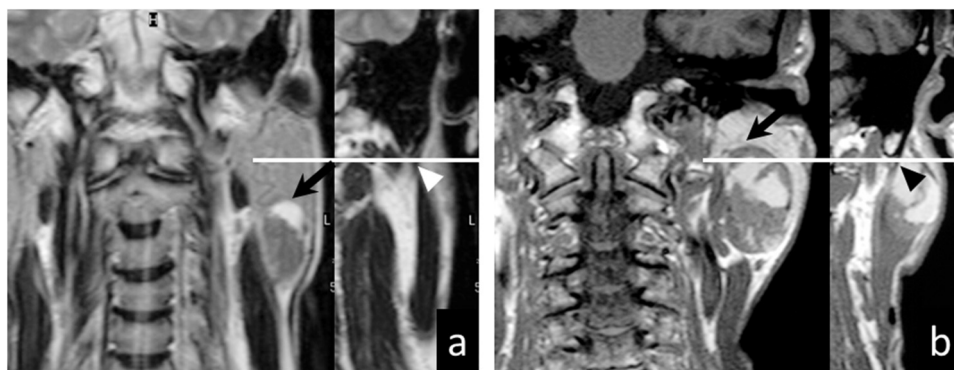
(A) Location of the tumour below the mastoid tip. The upper edge of the tumour (black arrow, a) can be seen below the mastoid tip (arrow head, a). (B) Location of the tumour above the mastoid tip. The upper edge of the tumour (black arrow, b) can be seen above the mastoid tip (arrow head, b). T2-weighted coronal MR image (a, b).
